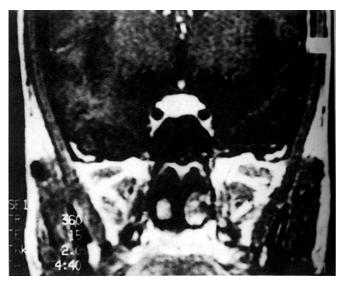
T₁-weighted coronal MR image after gadolinium enhancement showing a right-sided hypointense lesion in the anterior lobe of the pituitary gland, suggesting pituitary microadenoma
